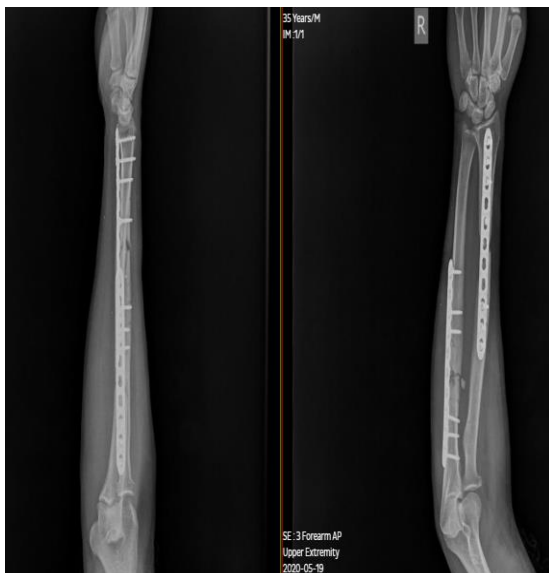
(b) Two months follow-up radiograph showing healing of the both bone fracture forearm and anatomical position of the radial head.
